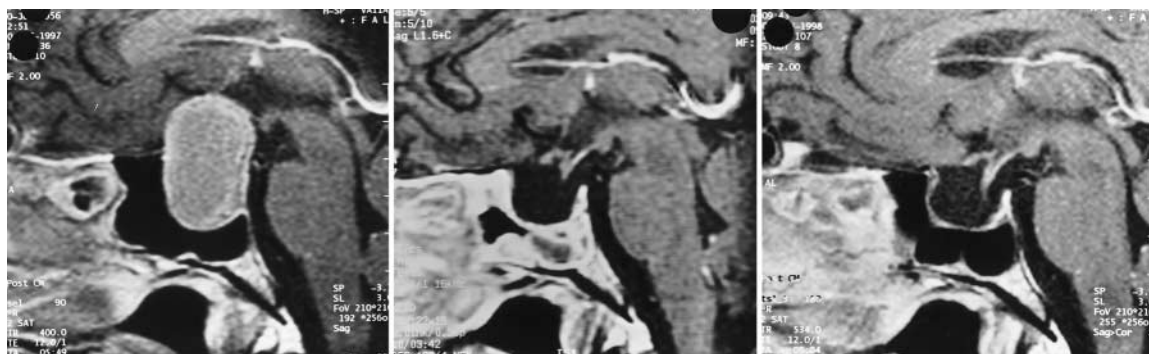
Sagittal T₁-weighted MR images obtained after intravenously administered Gd-DTPA in a patient with a pituitary macroadenoma. *Left*: Preoperative study. *Center*: Postoperative MR image obtained at 6 weeks, revealing a significant contrast-enhancing reaction mainly in the sphenoid sinus. *Right*: After 1 year, all of the introduced material has been resorbed, thus allowing identification of the sellar and infrasellar contents.
